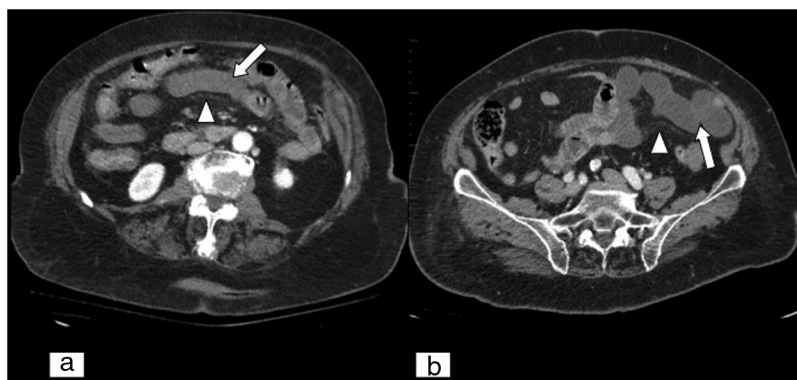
Abnormality in intestinal parietal uptake. (A) Abdominal and pelvic CT scan, axial plane, with iodinated intravenous contrast in an arterial phase (A) and in a portal phase (B). Loops of small intestine with decreased parietal uptake suggestive of ischaemia of arterial origin (white arrows) and mild striation of fat due to oedema are observed (white arrow tips).
